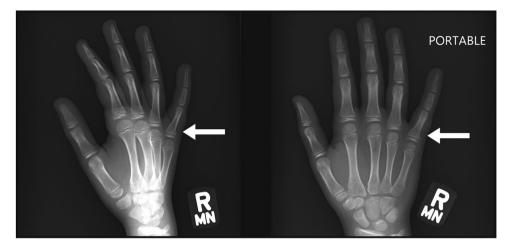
An x-ray was obtained showing a proximal fracture (as shown by the arrow)
